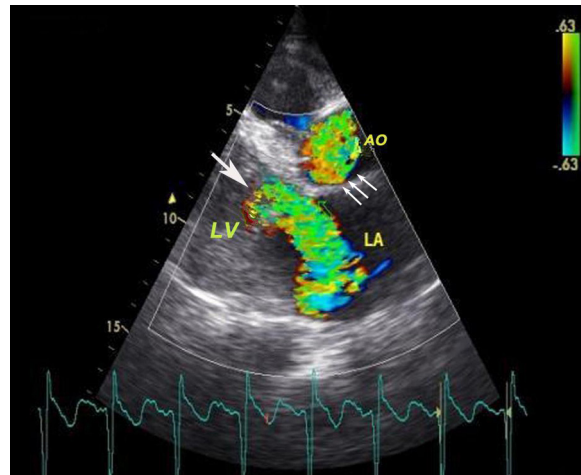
Parasternal long axis transthoracic echocardiography image at end systole, revealing two different turbulent jets, coming from mitral (big solid arrow) and aortic (small arrows) paravalvular leaks, due to prosthetic valves' dehiscence, with a fatal outcome despite of emergency repeated valve surgery. LV: left ventricle, LA: left atrium, AO: ascending aorta.
